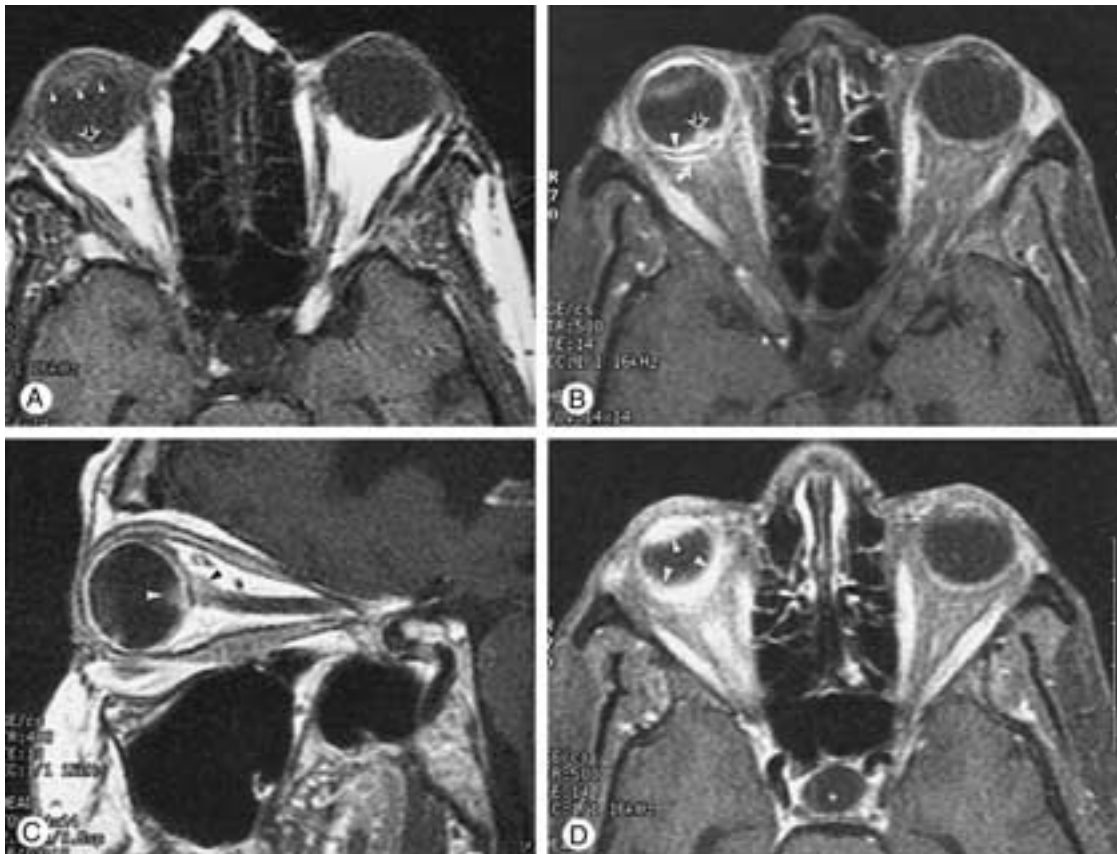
Ocular sarcoidosis panuveitis. A, Unenhanced, axial, T1-weighted (500/13, TR/TE) MR image shows nodular thickening of the posterior aspect of the right globe (*arrow*) and thickening of the anterior segment (*arrowheads*) of the right globe. B, Enhanced, axial, fat-suppressed T1-weighted (500/13, TR/TE) MR image shows nodular enhancement of the posterior aspect of the right globe (*arrowhead* and *open arrow*), related to granulomatous involvement of the choroid. Note enhancement of the anterior segment of the right globe. Notice abnormal enhancement of the Tenon's capsule (*curved arrow*). C, Enhanced, sagittal T1-weighted (400/13, TR/TE) MR image shows granuloma at the optic disc (*white arrowhead*) as well as involvement of the optic nerve (*black arrowhead*). D, Enhanced, axial, fat-suppressed T1-weighted (500/14, TR/TE) MR image shows enhancement of markedly thickened uveal tract (*arrowheads*). (From Mafee MF et al. Sarcoidosis of the eye, orbit, and central nervous system. Role of MRI. Radiol Clin North Am 1999;37:73–87.)
